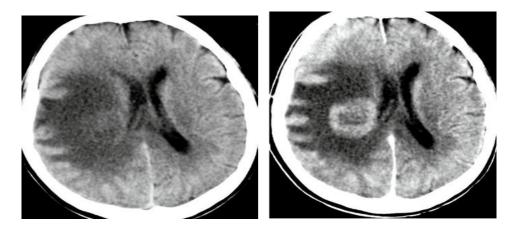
Enhancement of tumor after IV contrast administra-trast material identi es areas of BBB disruption facilitating the tion. (Left) CT before and (Right) after contrast administration. The detection of the neoplastic tissueneoplasm is clearly demonstrated on post-contrast CT(16
